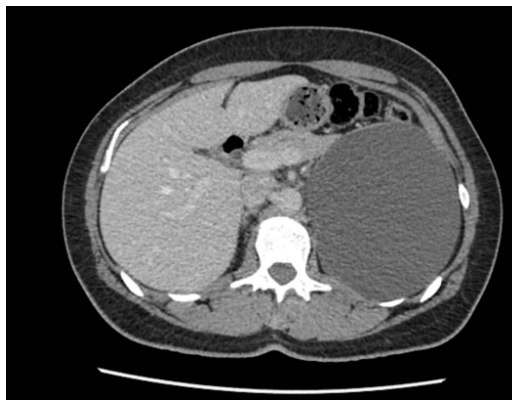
Cross section CT image observation left kidney cyst.
